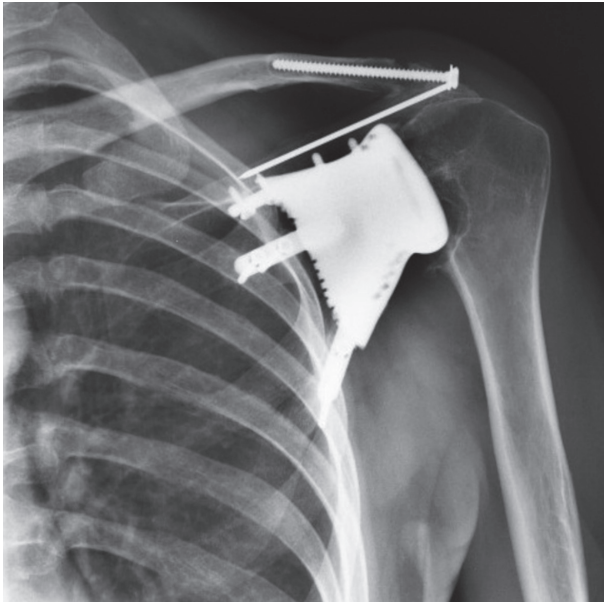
Five year follow-up x-ray
